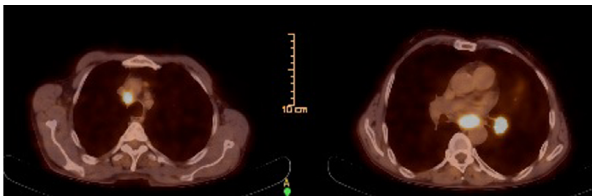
Lesion in the left hilum, right upper paratracheal and subcarinal lymphadenopathy on PET-CT.
